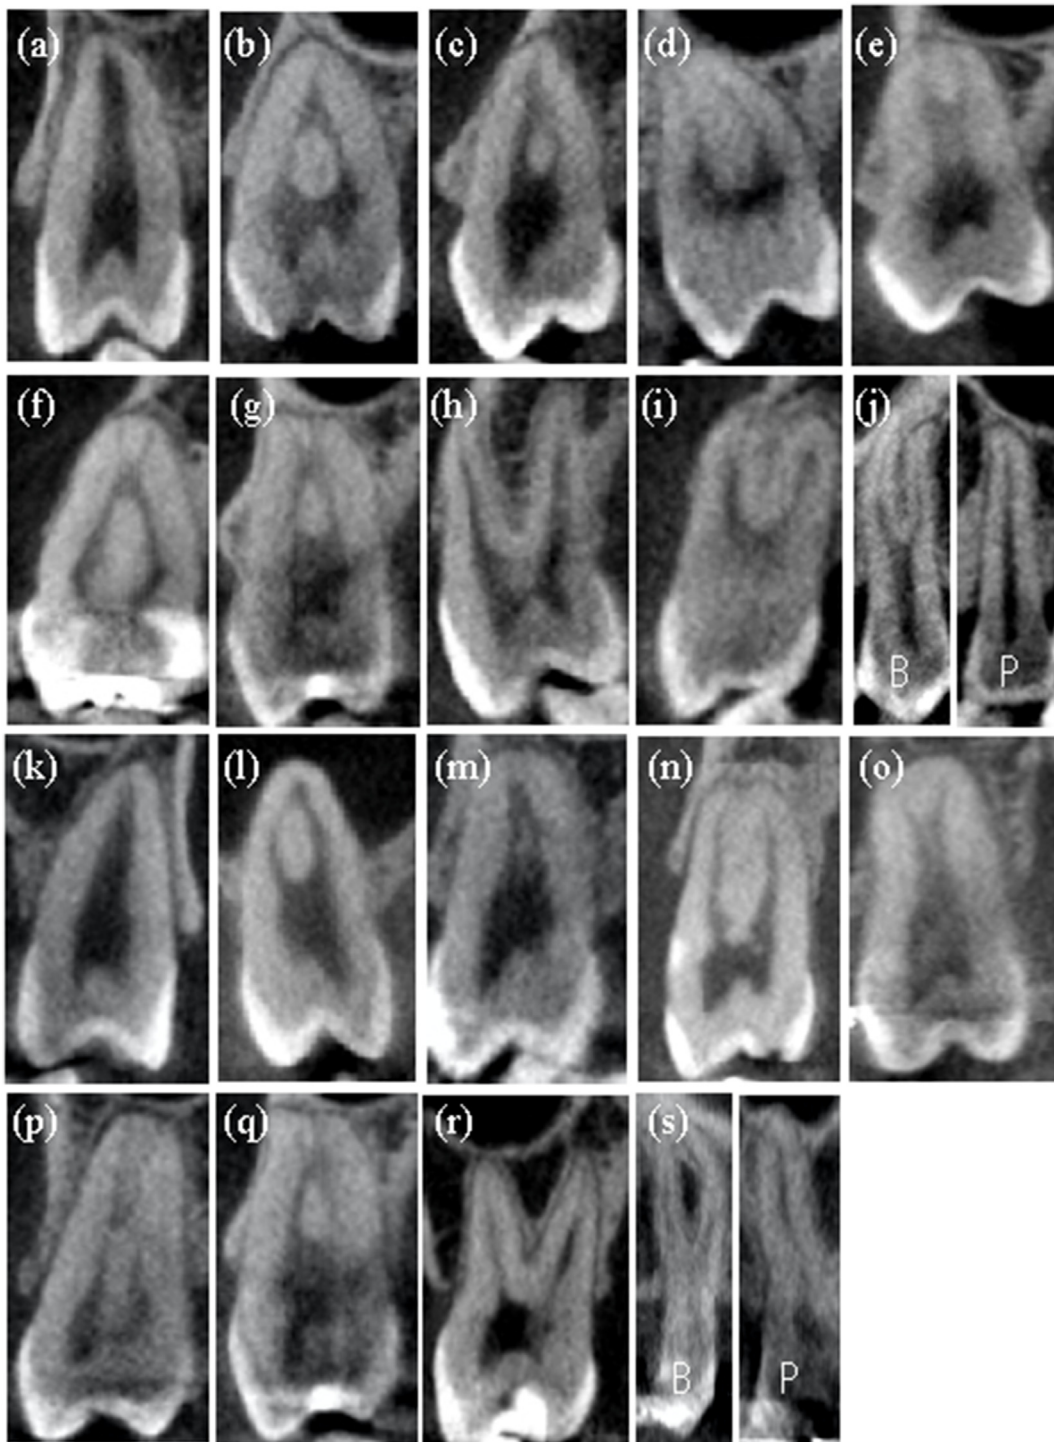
Representative CBCT images of different root canal system configurations in maxillary premolars.
